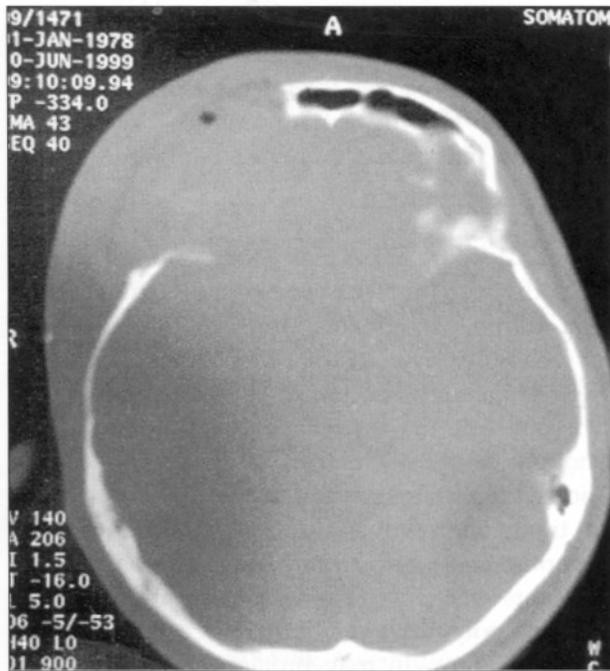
Axial (a) and coronal (b) computed tomography scans of the patient after cranioplasty with porous polyethylene
